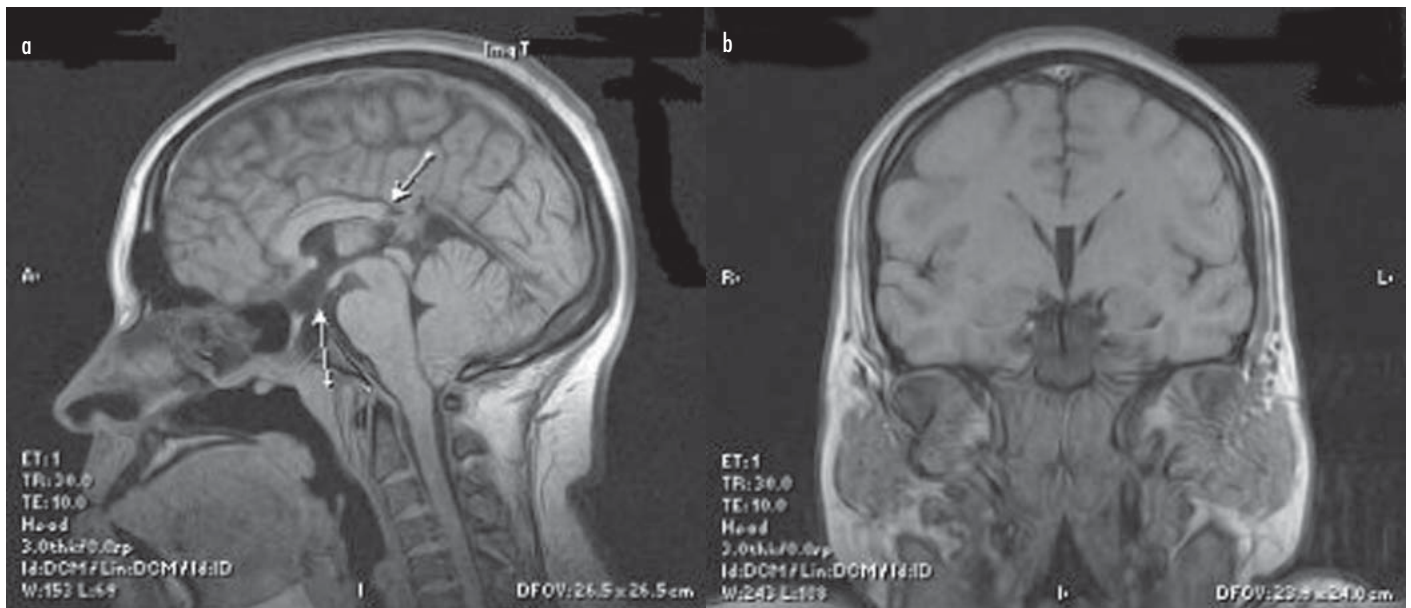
Magnetic resonance image of the brain (a) sagittal view and (b) coronal view showing the defect in the skull base extending through the sphenoid into the nasopharynx with extension extrusion of a sac containing CSF with stretching of the hypothalamus, the optic chiasm and pituitary gland through the defects. Optic nerves appeared normal. Anterior portion of the corpus callosum was present but posterior portion was absent (white arrows).
